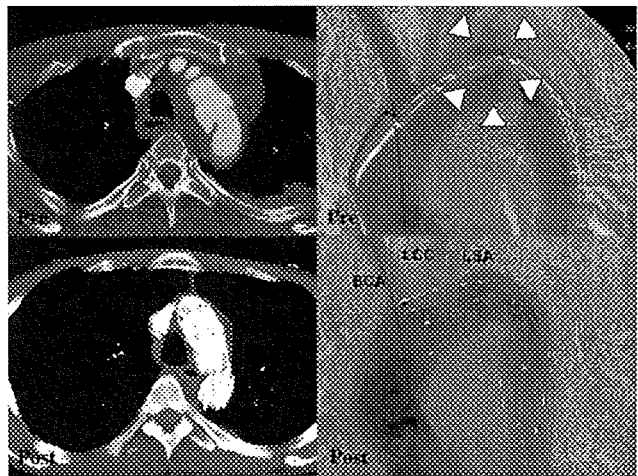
CT and DSA images obtained from a patient who underwent stent-graft treatment of aortic trauma. Preoperative and postoperative CT images (left) show, respectively, a massive mediastinal hematoma and complete resolution of the hematoma. Preoperative and postoperative DSA images (right) show, respectively, the aortic injury (white arrowheads) and complete exclusion of the pseudoaneurysm resulting from the injury. In this case, the LSA was simply covered with a stent-graft, whereas the brachiocephalic (BCA) and LCCA were well preserved by placement of a fenestrated stent-graft. The LSA was seen by retrograde blood flow.
